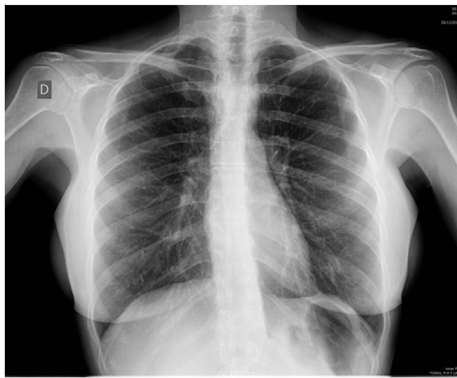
Posteroanterior thoracic X-ray, observing a narrowing of the tracheal lumen in the aortic button, which shows an atypical morphology.
